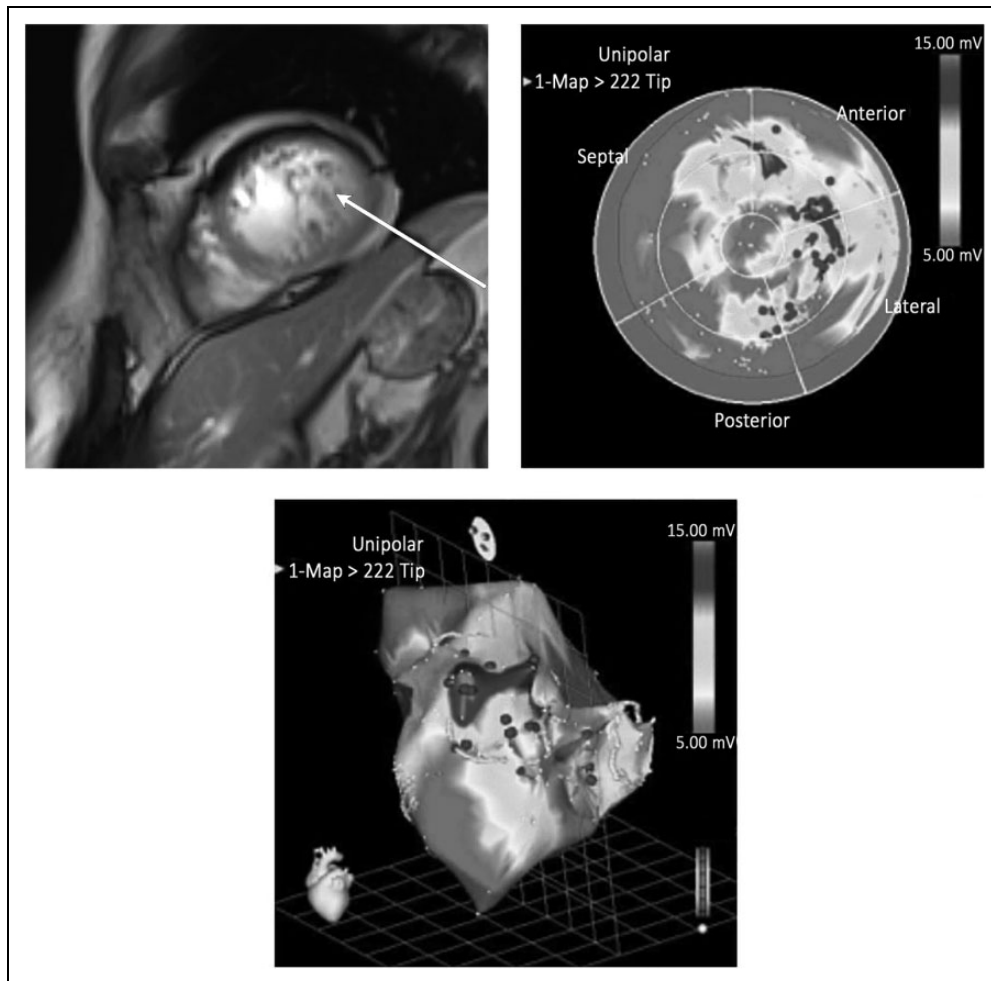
In trabeculated areas, confirmed by MRI (left panel, trabeculations marked with an arrow), transendocardial CD34⁺ cell injection was performed (middle panel, 3D reconstruction below). MRI: magnetic resonance imaging.
